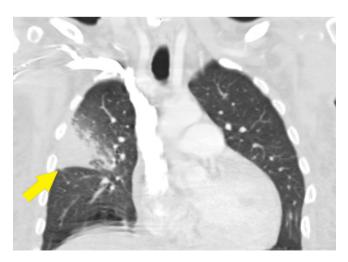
CT chest with intravenous contrast. There is dense consolidation and enhancement of the right upper lobe, which causes mass effect and bowing of the minor fissure (arrow). There are central areas of low attenuation suggesting necrosis or intrapulmonary abscess, and there is surrounding ground-glass opacity involving the majority of the inferior lateral right upper lobe.
